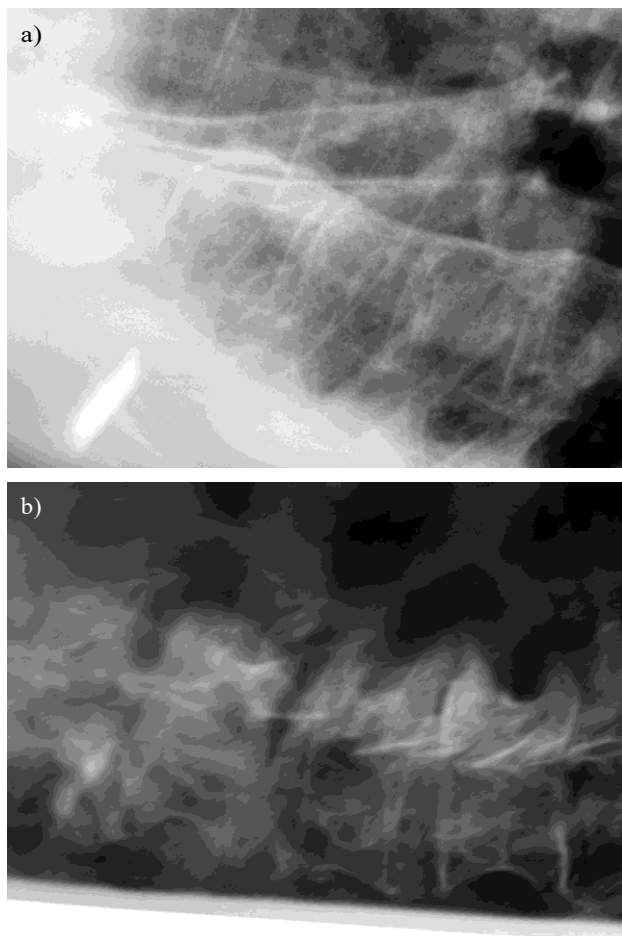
a, b. Radiographs of the thoracolumbal spine demonstrating paravertebral ossification (a), and flowing osteophytes on the ventral and lateral sides (b).
